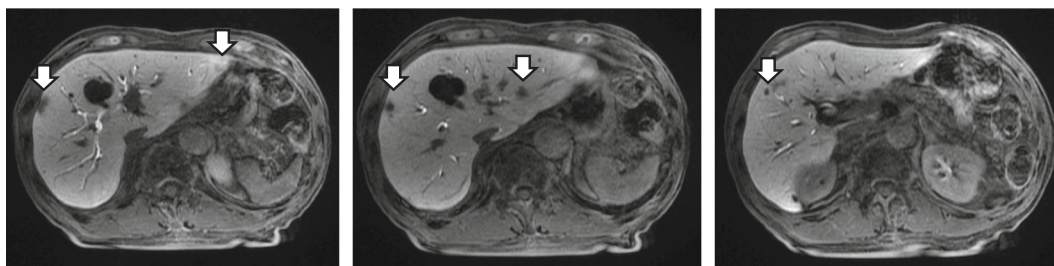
MRI findings. MRI after chemotherapy showing prominent reduction of multiple masses in both lobes of the liver in the hepatocellular phase (white arrow).
